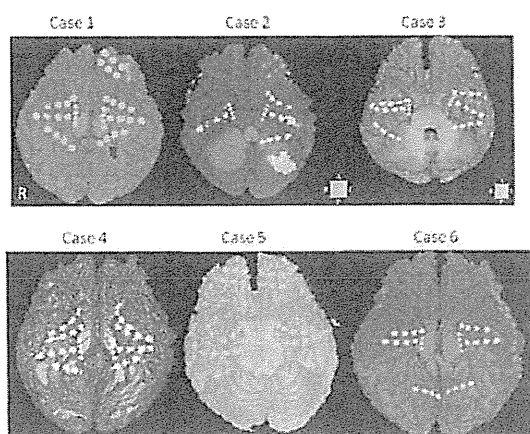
The location of the subdural electrodes on both the temporal bases (cases 1-6) The electrodes were registered by 3D-magnetic resonance imaging (MRI) in each patient. On the temporal base, the grids were placed almost symmetrically.
